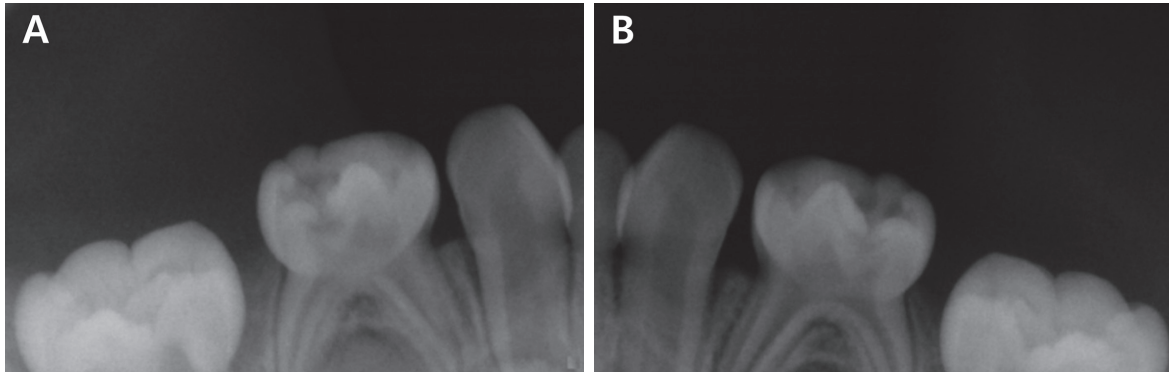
Preoperative periapical radiography (A) Right (B) Left.
